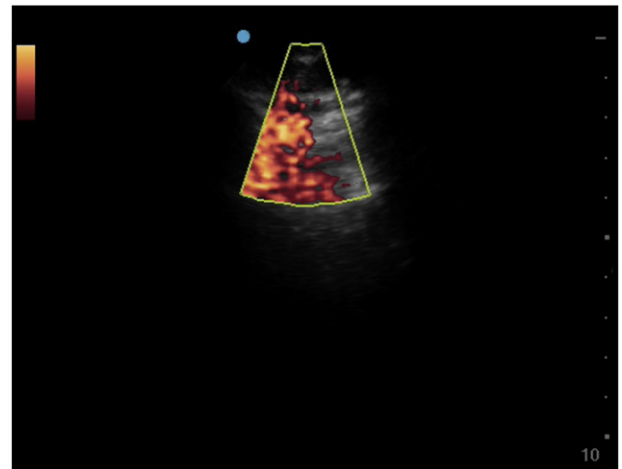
Low frequency probe. Normal lung. Power doppler image demonstrating doppler flow below the pleural line.
